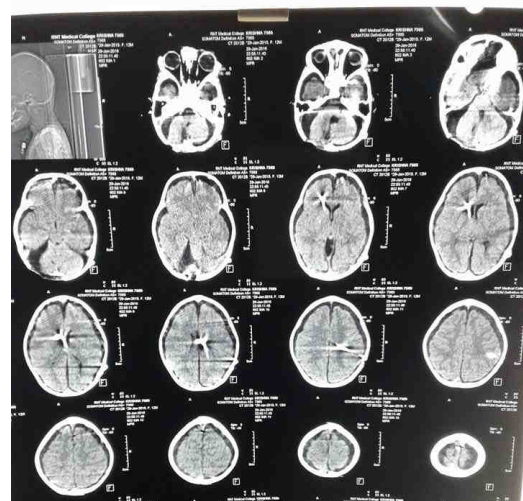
CT head post VP shunt
